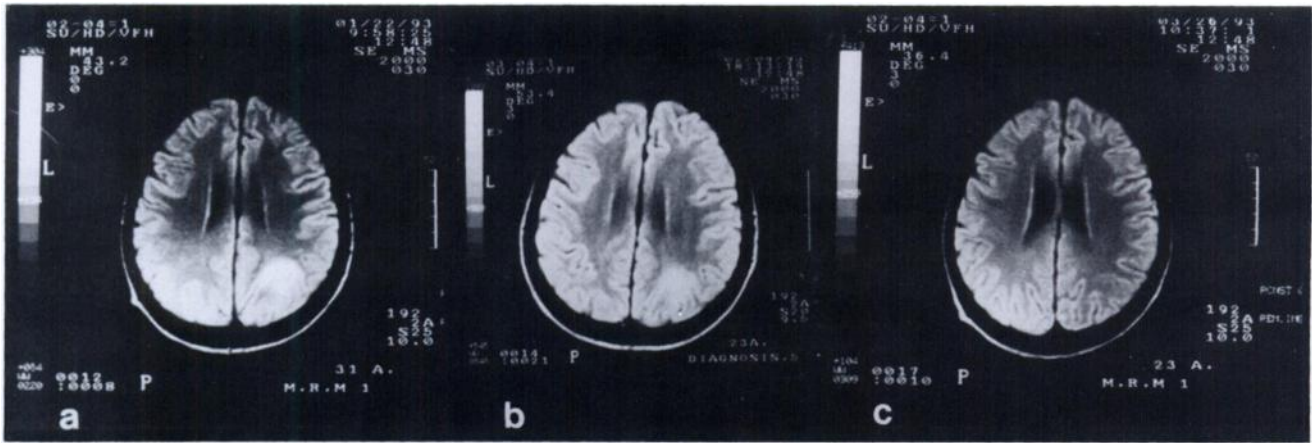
T2-weighted MRI images (with Gd-DTPA) show: (a) right parieto-occipital lobe lesion (3 days after the onset of symptoms), (b) a residual lesion (1 mo later) and (c) no abnormalities (3 mo later).
